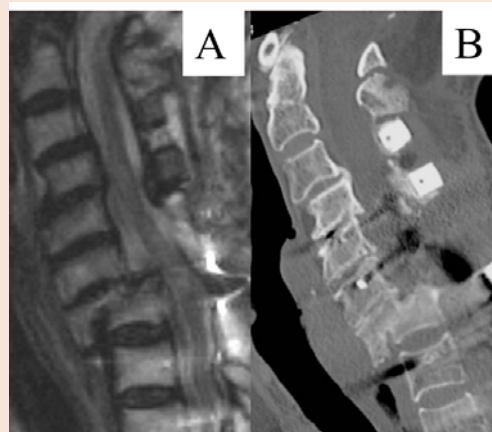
MRI T2-weighted sagittal image (A) and CT (B) six months after the latest surgical treatment.
